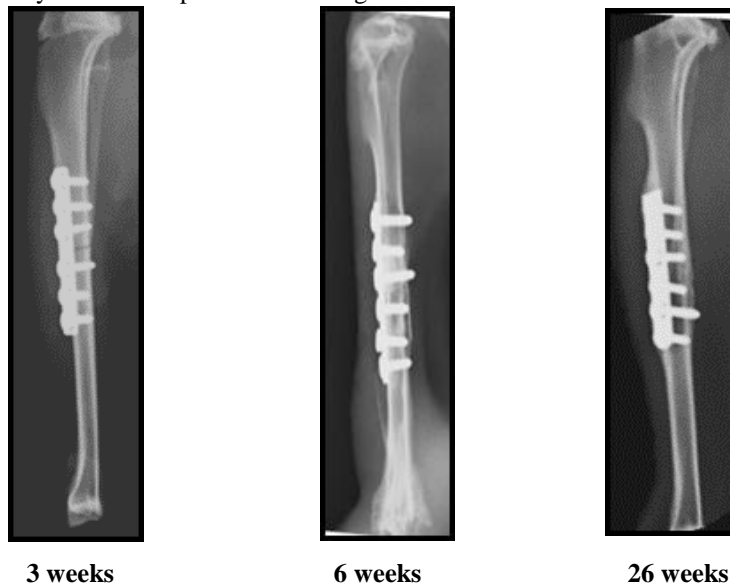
X-Ray assessment of implantation of MIM plate (lateral view) at different week
